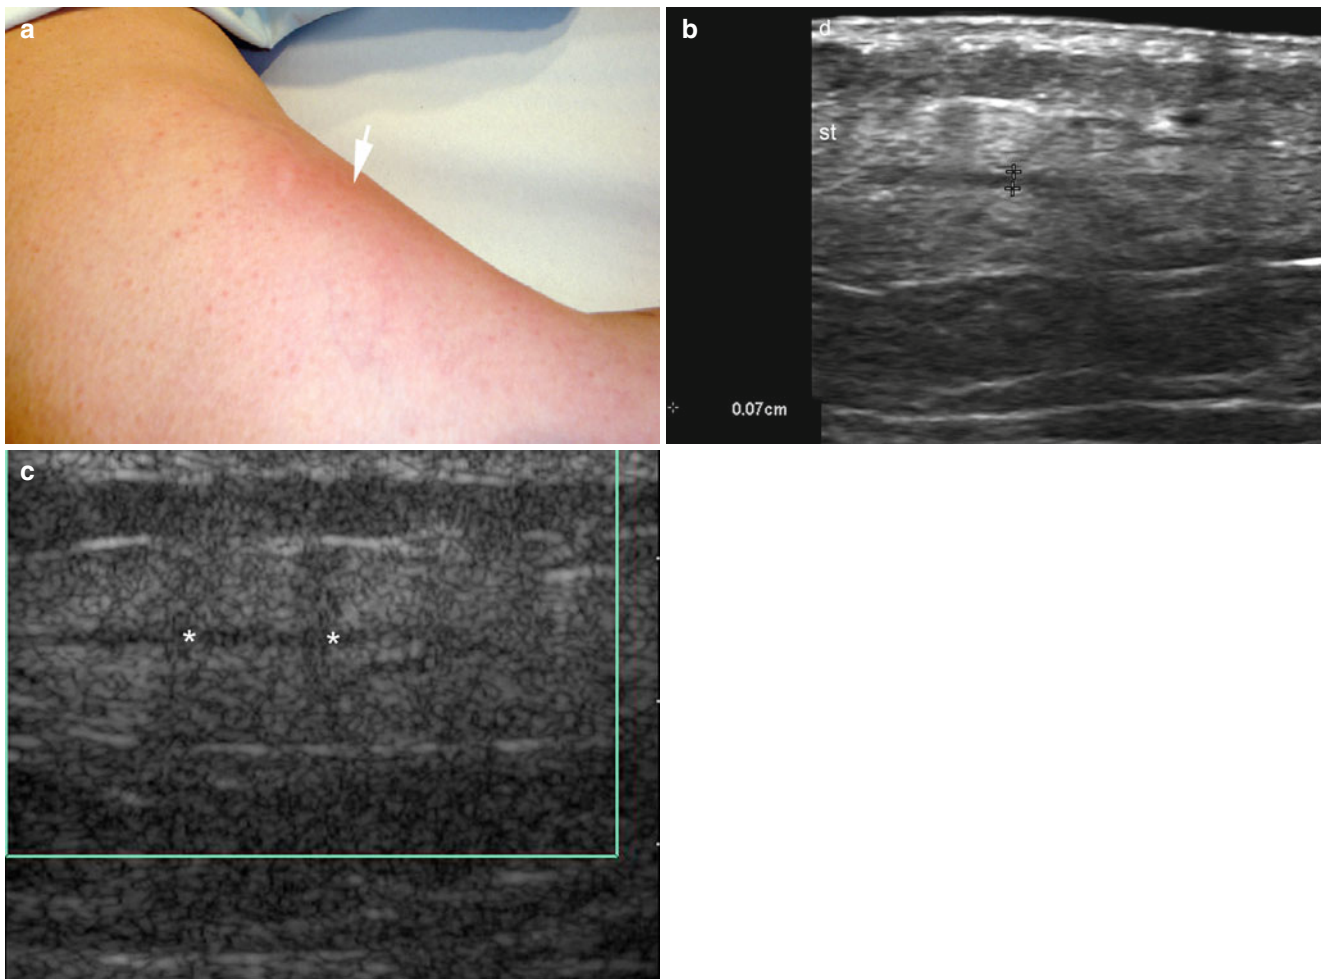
(a–c) Mondor’s disease. (a) Clinical image shows erythema (arrow) in the lateral aspect of the left flank. (b) Grey scale ultrasound image (longitudinal view) demonstrates a 0.7 mm (thickness) dilated, non-compressible and hypoechoic subcutaneous vessel (*, between
